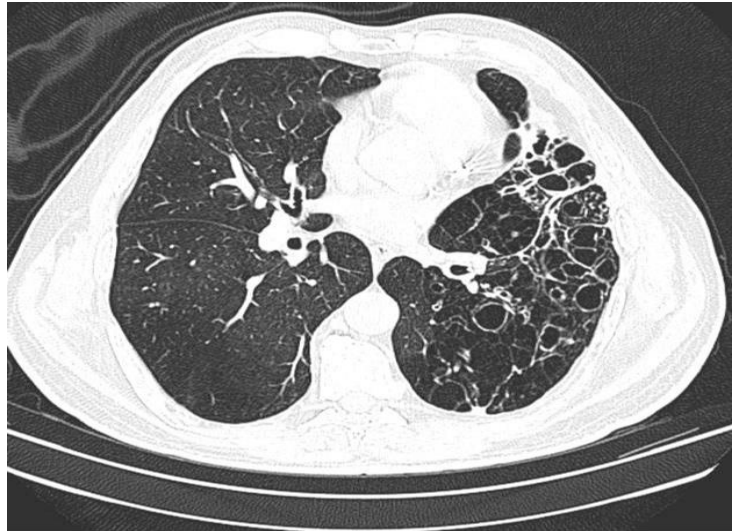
Image Show; HRCT show bronchiectasis
